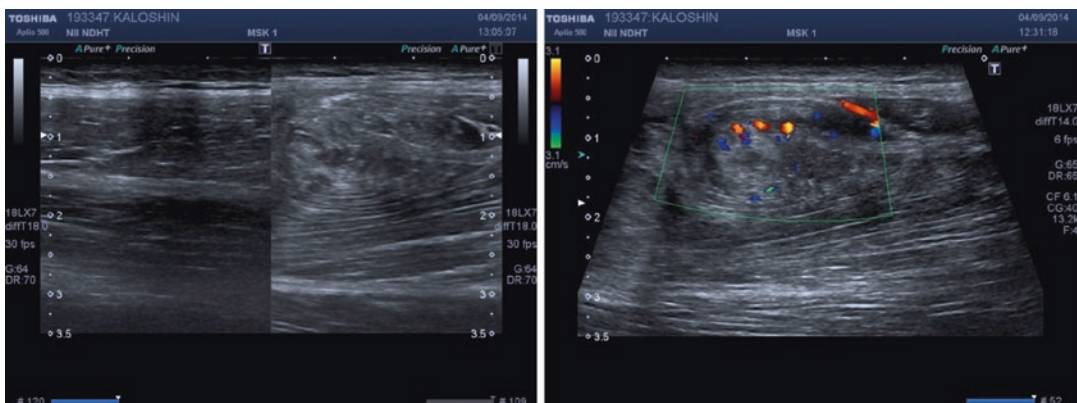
Ultrasound image (normal and injured muscle, vascular mode)
